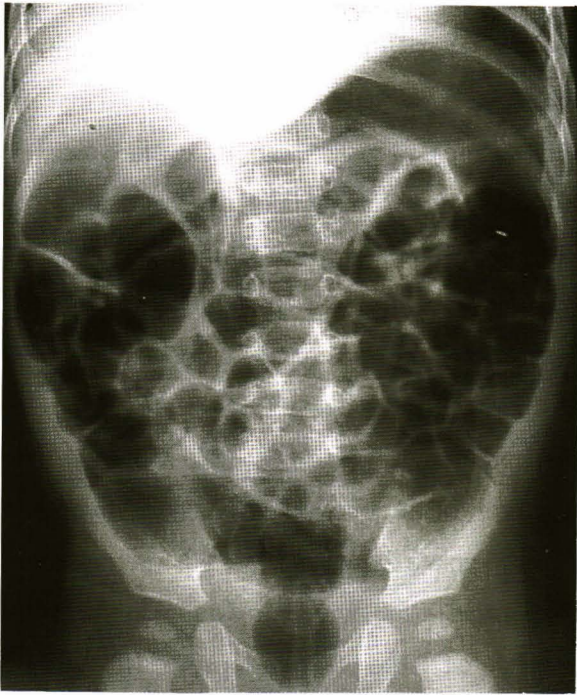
Plain radiograph of abdomen confirmed the complete reduction with loss of mass. There is generalized air-filled bowel.
